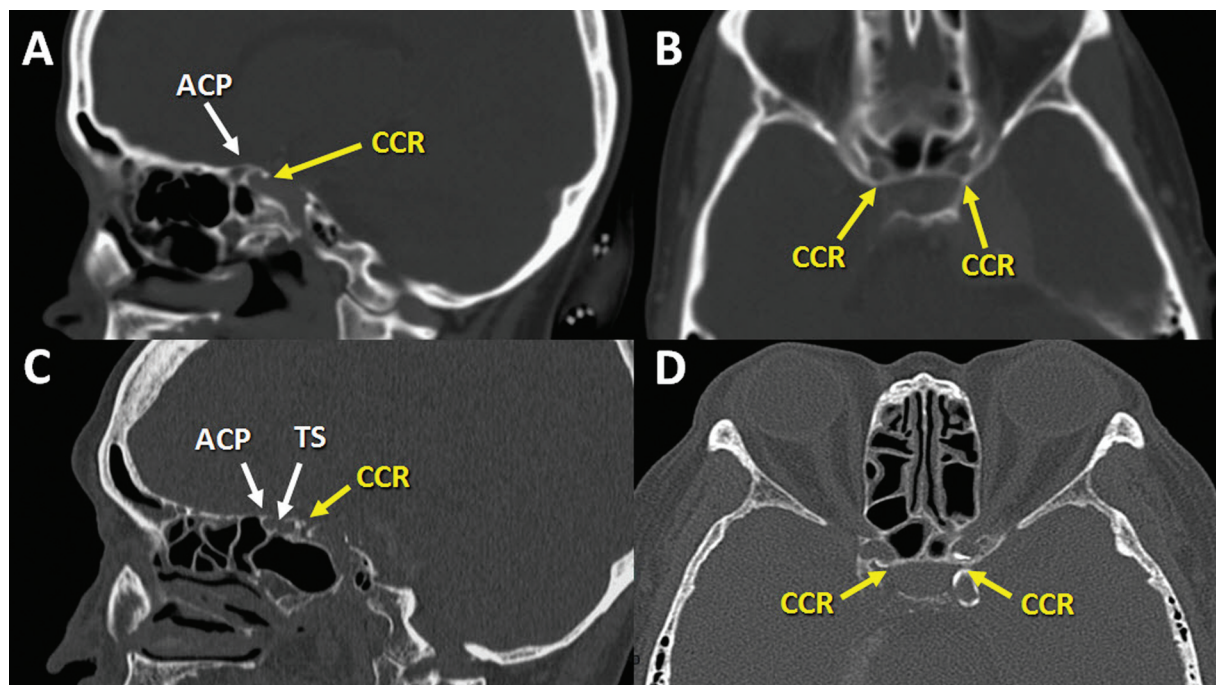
Bone window of cranial computed tomography showing CCR (complete type of middle clinoid process) in a patient with pituitary adenoma in sagittal (A) and axial planes (B), and in a patient without sellar lesion in sagittal (C) and axial planes (D). ACP, anterior clinoid process; CCR, caroticoclinoid ring; TS, tuberculum sellae.
